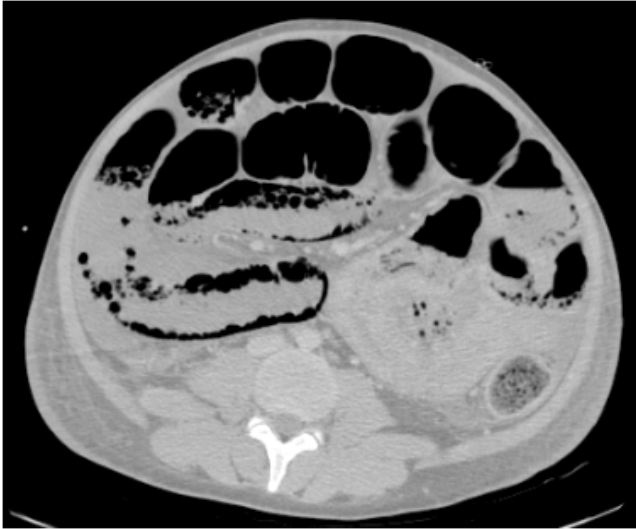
CT shows pneumatosis intestinalis as bubbly lucencies within the bowel wall in this patient with multi-system failure suggesting small bowel ischaemia.
